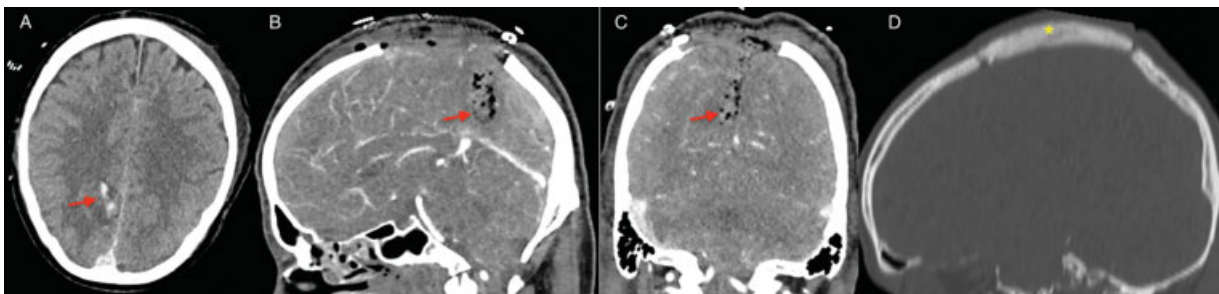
Postoperative axial CCT (A) and sagittal (B) and coronal (C) CTA confirm complete removal of all bone fragments and the foreign body. Small blood clot and minor intraparenchymal air are detectable (red arrow). (D) PMMA cranioplasty is shown (yellow asterisk). CCT, cranial computed tomography; CTA, computed tomography angiography; PMMA, polymethyl methacrylate.
